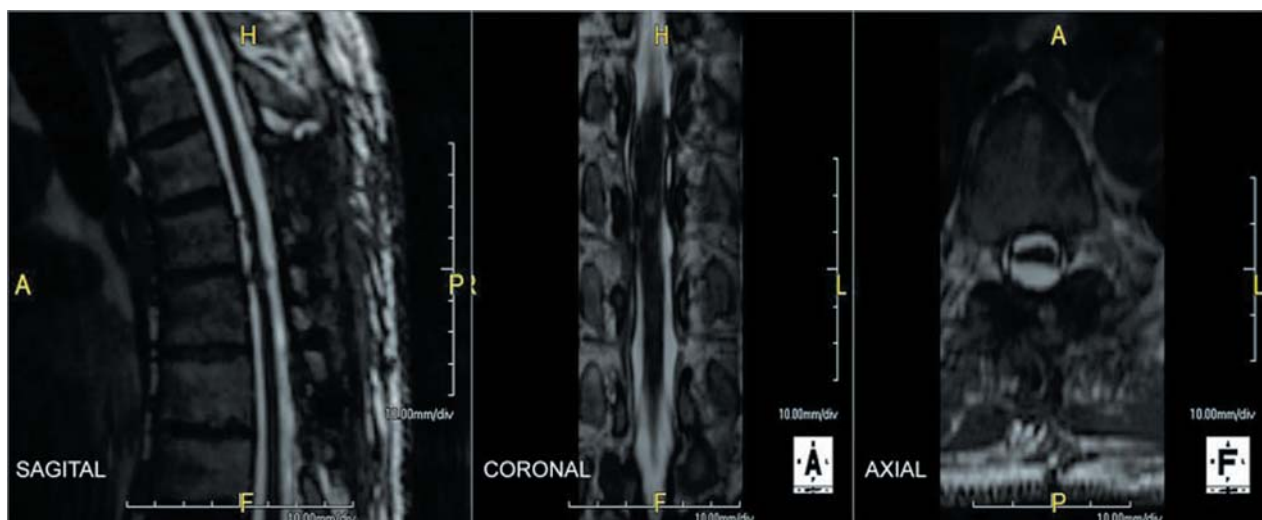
Control magnetic resonance imaging exam in sagittal, coronal and axial views. The spinal cord is returned to its position after surgery.
